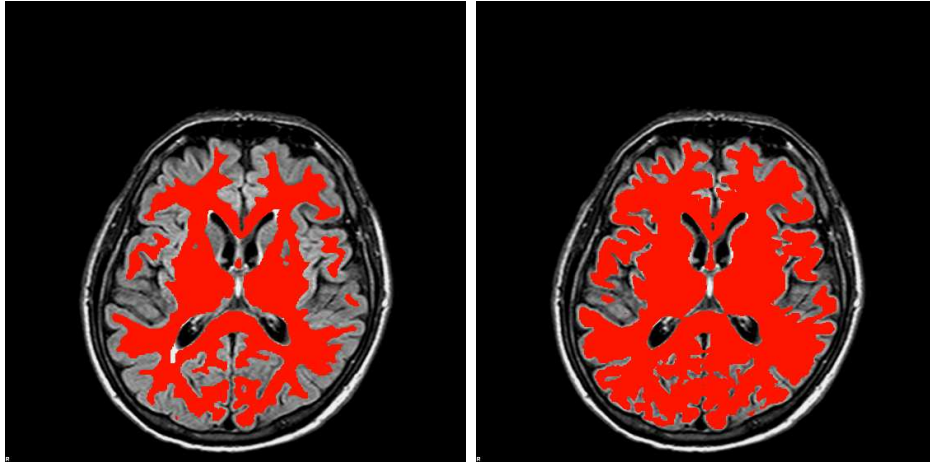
Tissue and WM Masks Overlaying a FLAIR Image. The image on the left is overlaid with the cerebral white matter mask. The image on the right is overlaid with the cerebral tissue mask.
